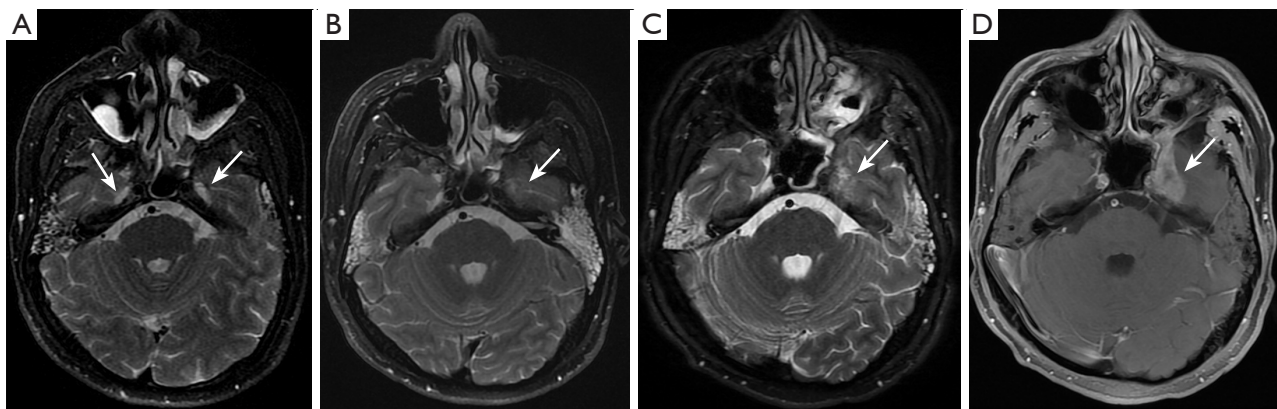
Blind spot in brain imaging: Meckel's cave. Scans of a 39-year-old male after radiotherapy for nasopharyngeal cancer. (A) In the initial period of follow-up, brain MRI revealed no abnormalities, and T₂WI showed symmetrical high-intensity signals resembling cerebrospinal fluid in bilateral Meckel's cave (arrows). (B) Three months later, the high-intensity signal on T₂WI in the left Meckel's cave disappeared (arrow), suggesting the possibility of recurrence. (C) In the subsequent examination, the T₂WI high-intensity signal in the left Meckel's cave was consistently not visualized, revealing the emergence of an abnormal soft tissue-like signal (arrow). (D) Enhanced scans indicated a recurrence of nasopharyngeal cancer that involved the left Meckel's cave (arrow). MRI, magnetic resonance imaging; T₂WI, T2-weighted image.
